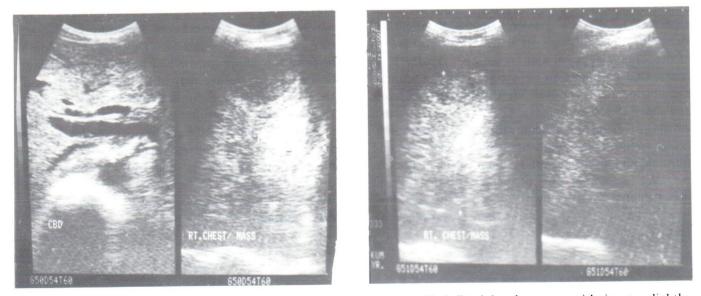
Ultrasonography in the region of the mass revealed a well defined border mass with iso to slightly hyperechoic to the liver parenchyma and there were areas of low echo. The liver was normal.
